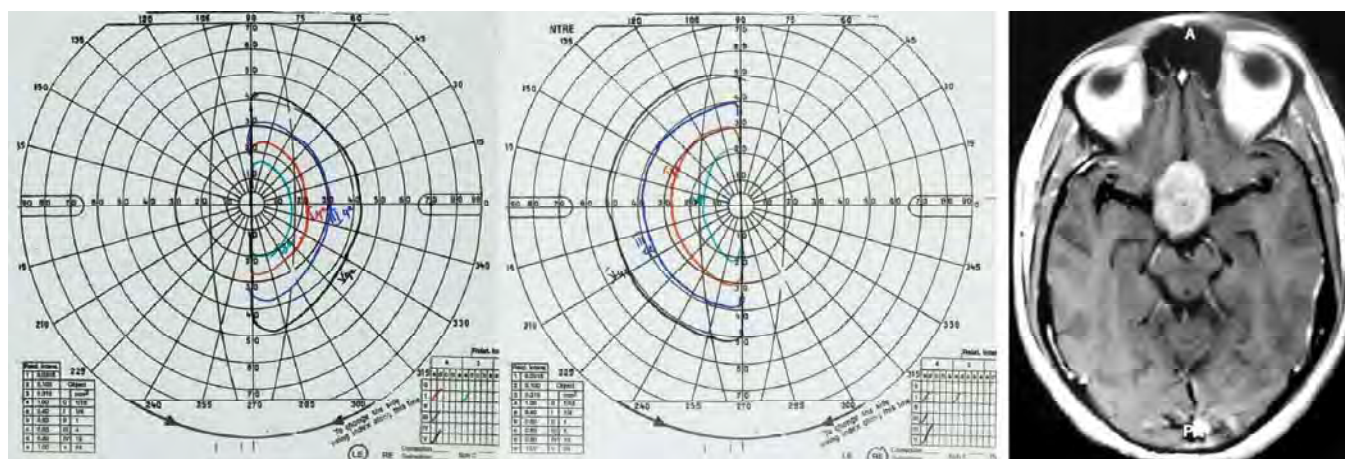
Bitemporal hemianopia in a case of pituitary adenoma. MRI of large pituitary adenoma
